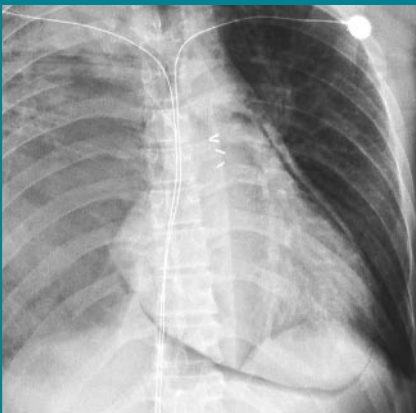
Chest radiograph shows pneumopericardium.
